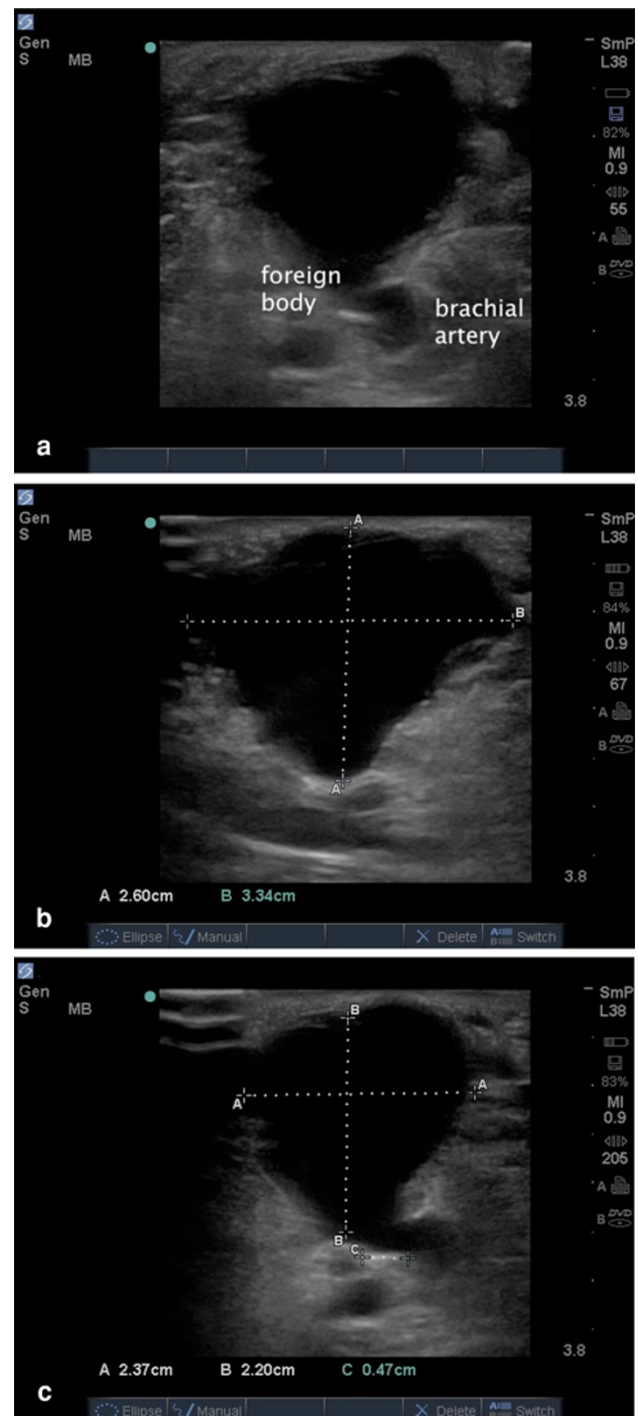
a–c Ultrasound images of the anechoic structure and measurements
